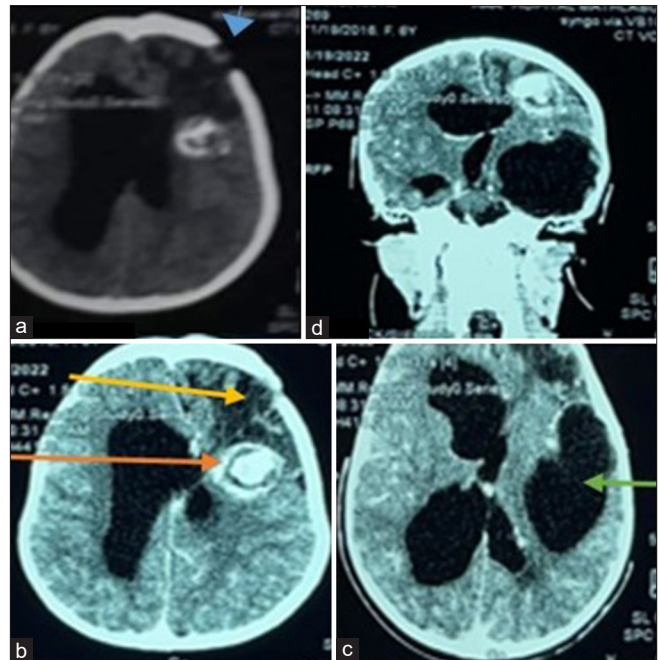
Cerebral computed tomography (CT) scan, parenchymal window (a) without contrast and (b-d) with contrast. (a) It is an axial view showing a bony defect (blue arrow). (b) Shows an axial view of a cerebral CT scan showing a round lesion (orange arrow) with ring enhancement, a center with areas of hypodensity as well as hyperdensity (calcification) surrounded by perilesional edema (yellow arrow). (c) It is an axial view but lower than the slices in B, and it shows a cyst in the temporal lobe (green arrow). (d) It is a coronal view showing both lesions.
